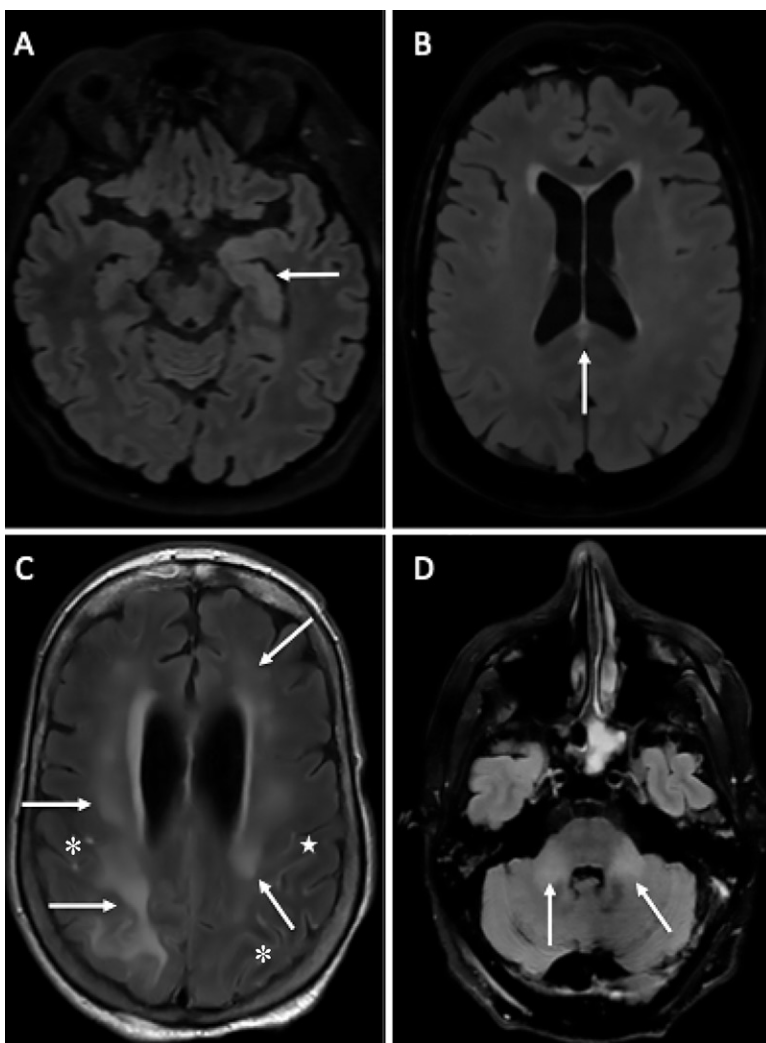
Axial fluid-attenuated inversion recovery (FLAIR) images in four different patients with coronavirus disease 2019. A, A 58-year-old man with impaired consciousness has FLAIR hyperintensities (arrow) in the left medial temporal lobe. B, A 66-year-old man with impaired consciousness has a FLAIR ovoid hyperintense lesion (arrow) in the central part of the splenium of the corpus callosum. C, A 71-year-old woman with abnormal wakefulness after sedation has extensive and confluent supratentorial white matter FLAIR hyperintensities (arrows) in association with leptomeningeal enhancement (*). D, A 61-year-old man with confusion has hyperintense lesions (arrows) involving both middle cerebellar peduncles.
